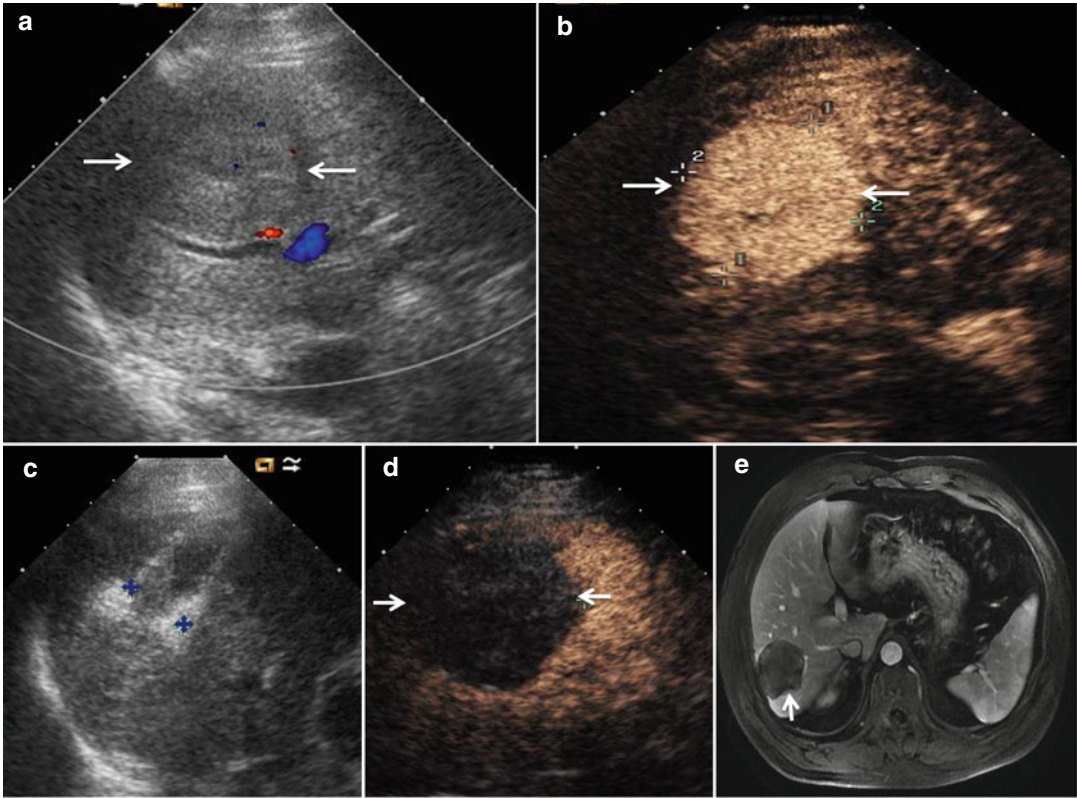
MWA in a 45-year-old woman with HCC on right lobe of the liver. (a) Preablation conventional ultrasound (US) scan shows a hypoechoic lesion with blood supply (arrows). (b) Contrast-enhanced US before MWA shows tumor enhancement in arterial phase with the size of 5.5×4.7 cm (arrows). (c) Conventional US shows
